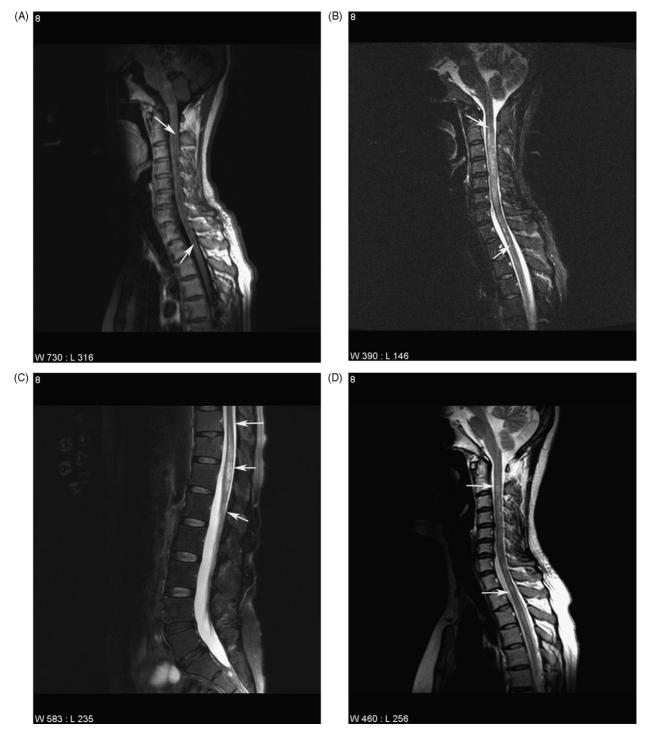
Magnetic resonance images of a 31-year-old lady with rapidly progressive acute disseminated myelitis (A–C, before treatment) show partial resolution of the long-segment demyelinating lesions 3 months after (D) short-term intravenous immunoglobulin and steroid therapy. Cervical cord MRI (A, B, and D) and lumbosacral cord (C). T1-weighted images (A) and T2-weighted images (B–D).
